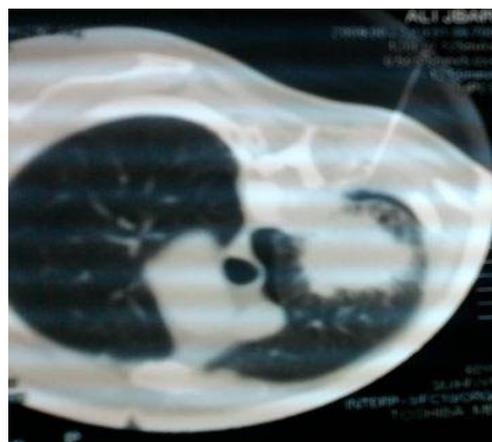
CT chest showing development of small pneumothorax after needle introduction.
